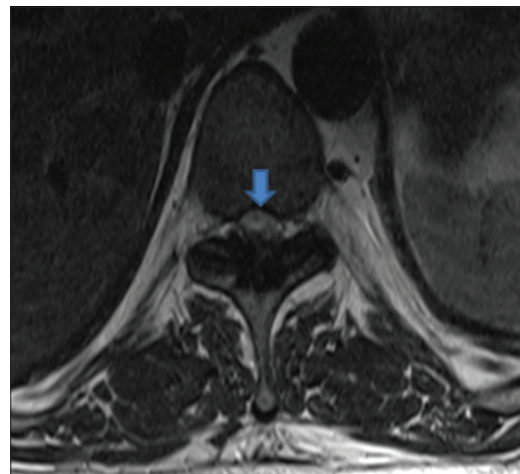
T2-weighted axial section at T10-T11 level showing ossification of ligamentum flavum with severe spinal canal stenosis and cord compression (arrow)
